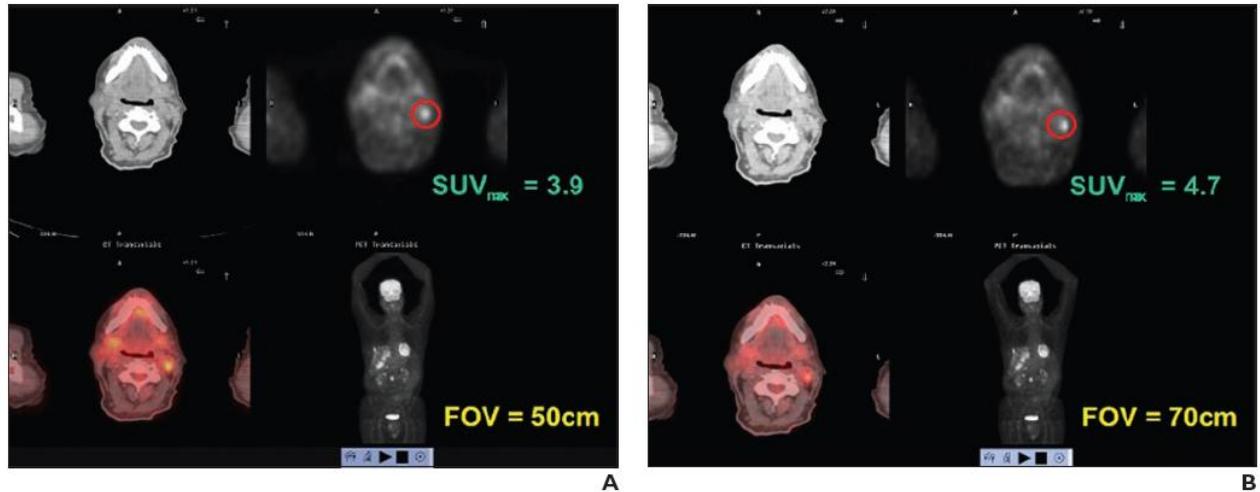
Effect of field of view (FOV) change on standardized uptake value (SUV) measurement of melanoma in 61-year-old man. Initial images were reconstructed with 50-cm FOV (A) and with 70-cm FOV (B) to include area of primary disease. Image reconstruction algorithm was the same for the two images (27).
